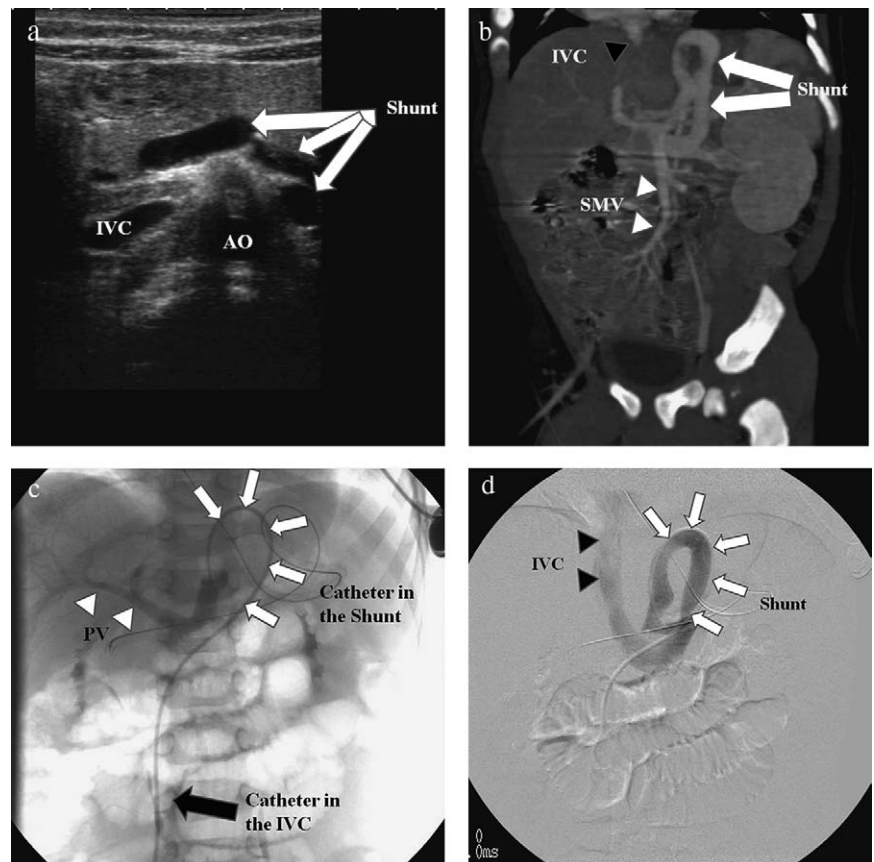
Extrahepatic portosystemic shunt. (a) Extrahepatic portal vein (PV)–inferior vena cava (IVC) shunt demonstrated on ultrasonography was more easily recognized on (b) multi-plane reconstruction of contrast-enhanced CT. (c,d) The shunt vessels were long enough, curved, and balloon-occludable. This patient underwent balloon-occluded retrograde transvenous obliteration with metallic coils. AO, aorta.
